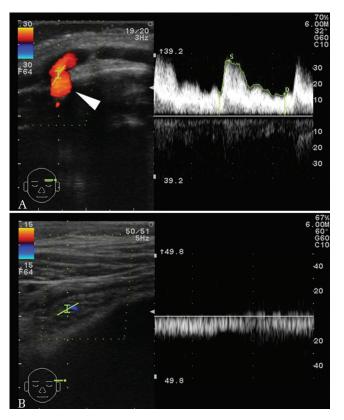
Venous outflow from the sinus pericranii on color Doppler ultrasonography. Upper panel: An arterialized phasic pattern was detected in the left superior eyelid. The arrowhead indicates a bone hole in the left supraorbital rim. Lower panel: The vascular structures in the left superior eyelid were compressed by strong retraction of the skin flap, leading the temporary disappearance of venous flow and the phasic pattern.
